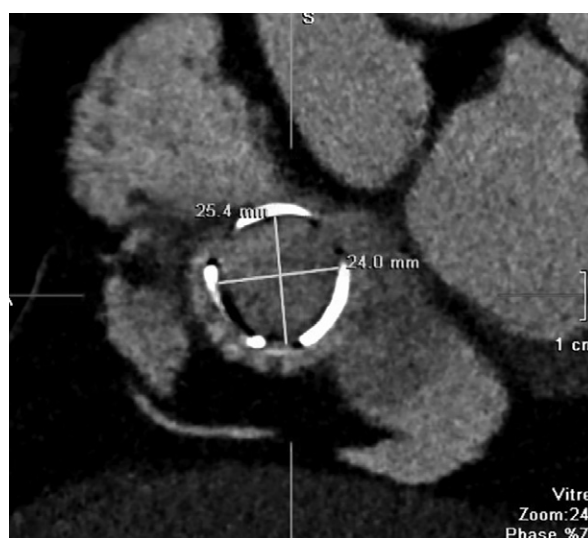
Computed tomogram shows the 27-mm Carpentier-Edwards® PERIMOUNT® bioprosthesis; measurements of the stent frame confirm the internal diameter of 25 mm.
